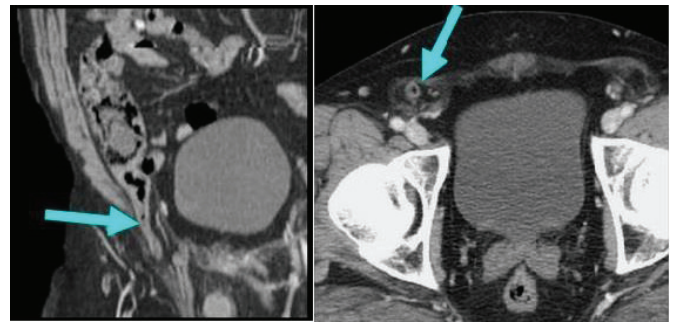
CT image objectivizing an intrahernal appendicitis [17,18].
